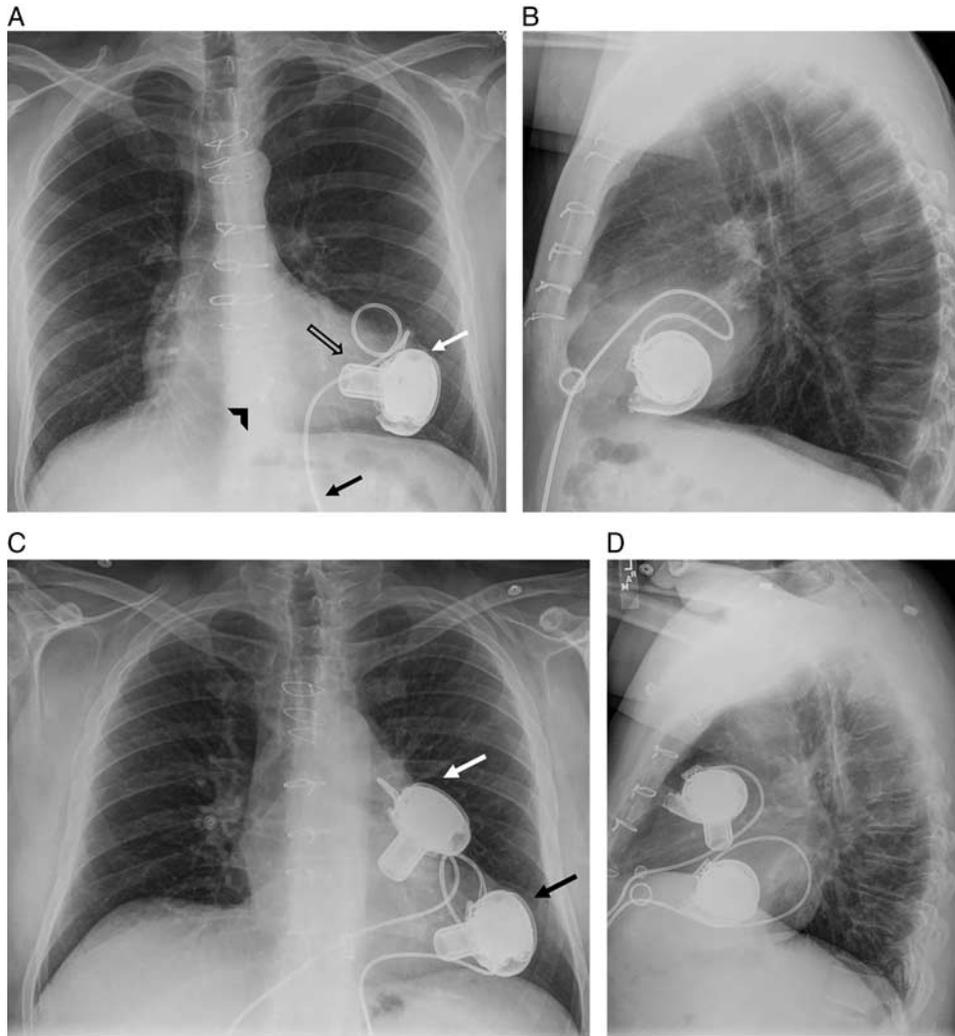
HeartWare LVAD: frontal (A) and lateral (B) radiograph depicting HeartWare LVAD. The entire pump apparatus (white arrow) is within the pericardial sac. The LV cannula is pointed toward the mitral valve (open black arrow). The outflow cannula to the ascending aorta is radiolucent (black arrowhead). The driveline (black arrow) extends beyond the field of view. Frontal (C) and lateral (D) radiograph depicting HeartWare LVAD (black arrow) and RVAD (white arrow).
